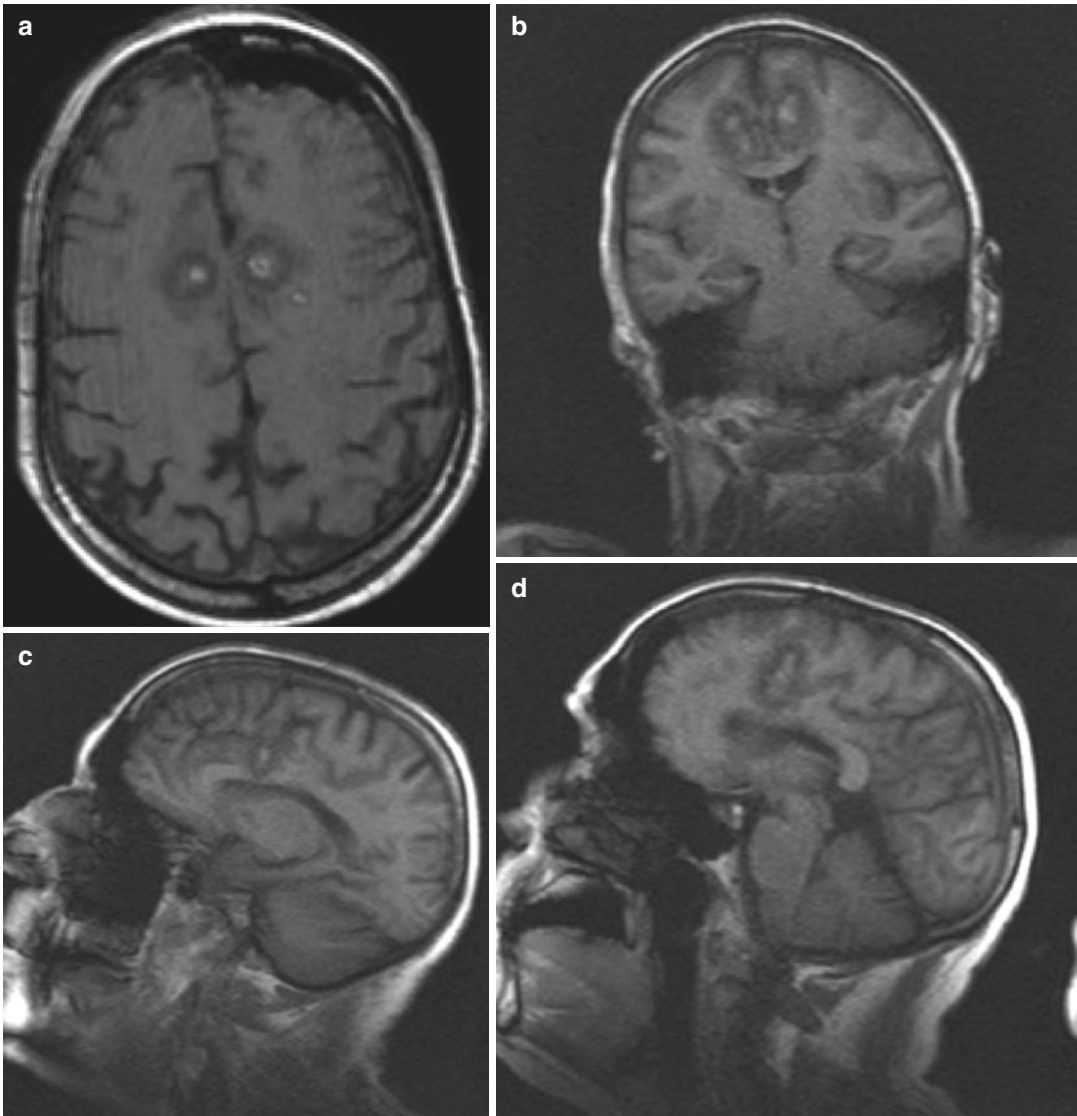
Postoperative MRI showing location of radio-frequency cingulotomy for medically refractory pain. (a) axial, (b) coronal, (c) parasagittal, and sagittal (d). (From
